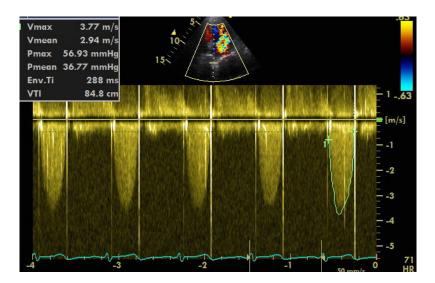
Transesophageal echocardiography of aortic valve showed mean gradient of 36.77 mm Hg
